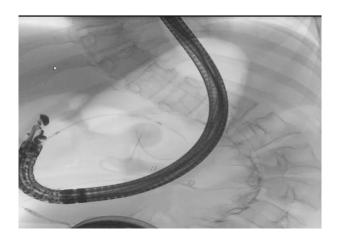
X-ray guided filling-catheter placement. Note the severe scoliosis.
